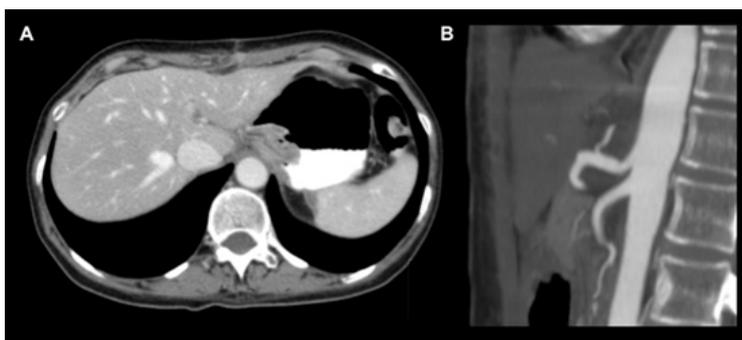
Contrast-enhanced follow-up CT angiography, taken one month after surgery. Axial view (A) and sagittal reconstruction (B) of the upper abdomen, showing respectively a residual small area of splenic infarct scarring (A) and a normal calibre celiac axis (B) after MAL division.
